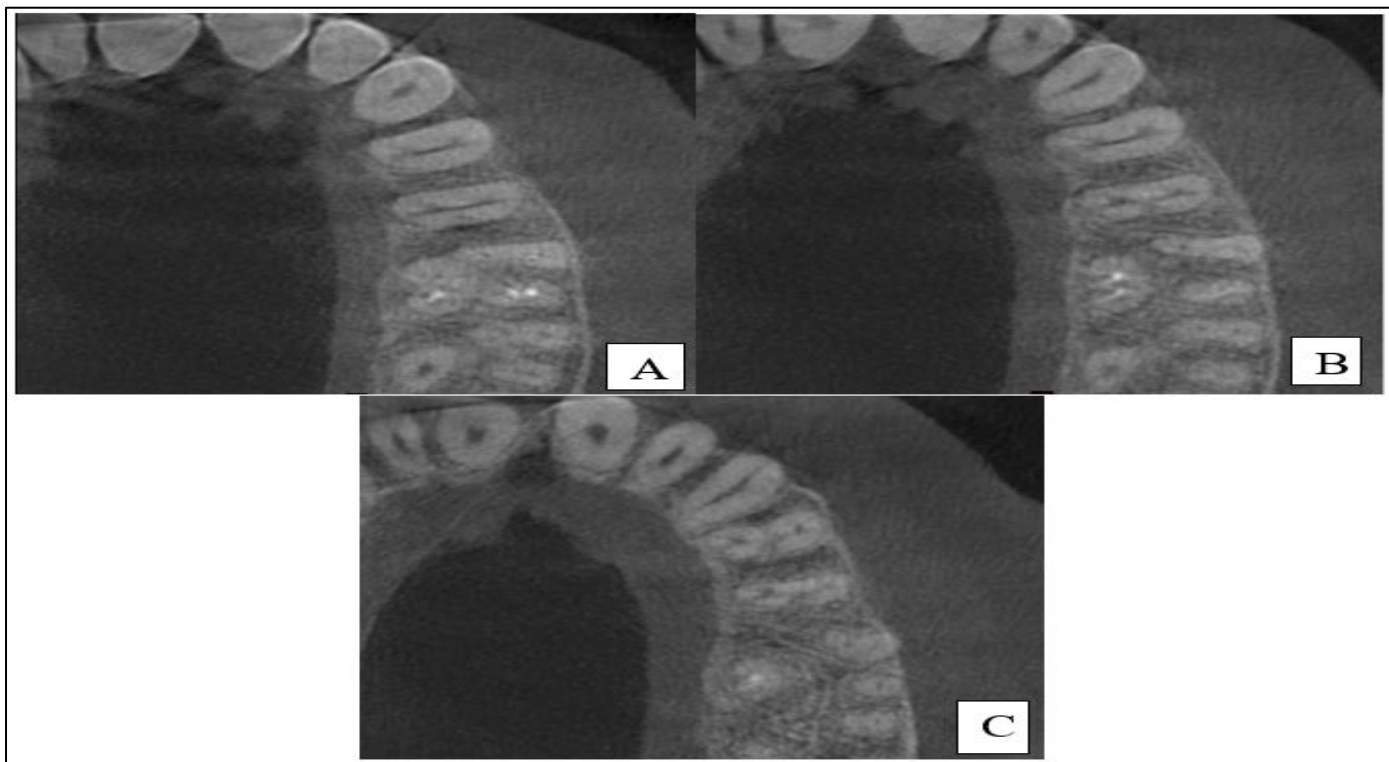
CBCT image: A: Coronal 1/3rd of the root canal showing two mesial, two distal and two palatal canals, B: Middle 1/3rd of the root canals showing two mesial, two palatal and merged distal canal, C: Apical 1/3rd of the root canal showing two mesial, one distal and one palatal canal.
